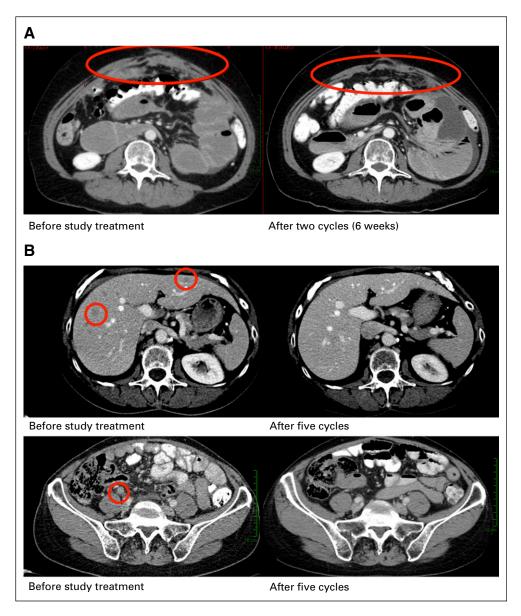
Computed tomography scan images of two patients. (A) In the first patient, peritoneal lesions growing into the abdominal wall decreased to residual lesions after two cycles of study treatment. (B) In the second patient, liver lesions and a pathologic lymph node before start of treatment disappeared after five cycles of study treatment.
